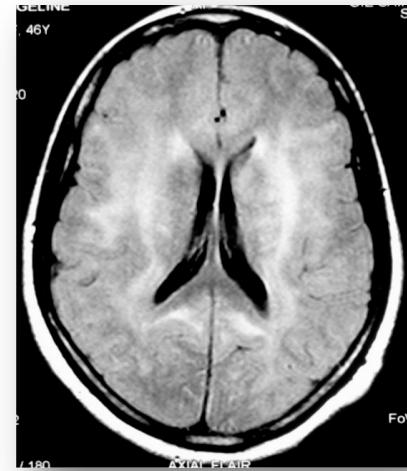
White-matter abnormalities on CT and MRI
